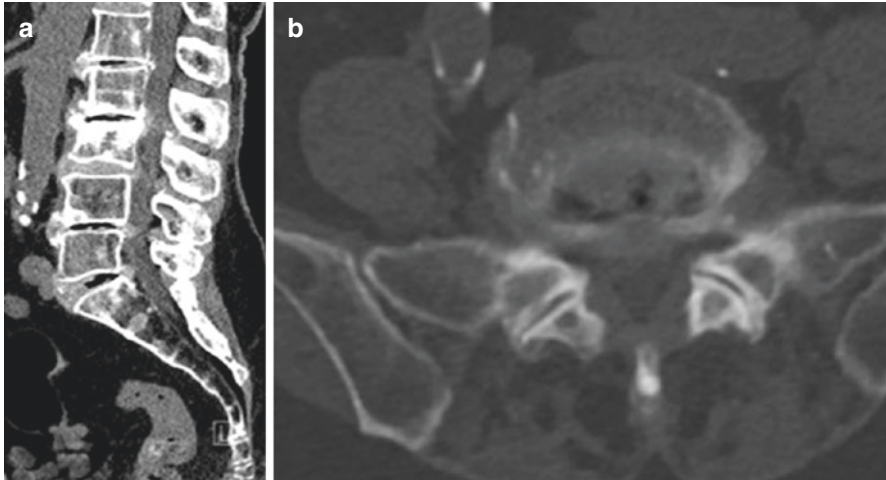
Computed tomography of the spine of a 76-year old female presenting with excruciating lower back pain during the last 2 months. Fractured L3 vertebra and multiple calcified intervertebral disks, protruding into the spinal canal are evident (a). Facet joints with osteoarthritic hypertrophic changes are shown at axial section (b). All reported imaging findings can serve as potential pain sources. The clinical diagnosis was most compatible with facet joint pain, originating in the right L5-S1 facet joint, and it was confirmed by an immediate and almost full disappearance of pain after local injection of betamethasone/esracain
